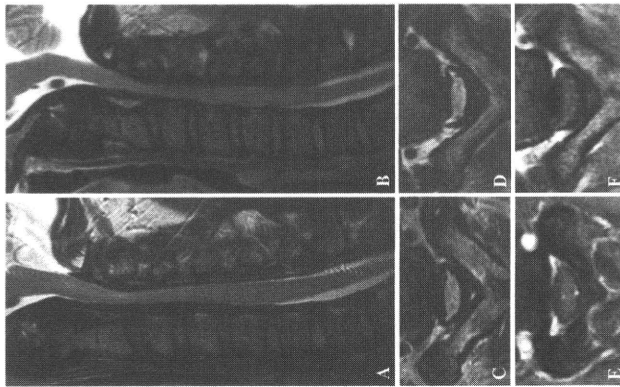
MRI of the cervical spine of Patients 1 (A, C, E) and 2 (B, D, F). A, B, D, F showed severe cord compression at C2-6, surrounded by thickened dura mater. The thickened dura was moderately homogeneously enhanced with gadolinium contrast. A-D, T2-weighted images; E, F, T1-weighted image with gadolinium enhancement; C, F, axial sections at C2/3 level.
